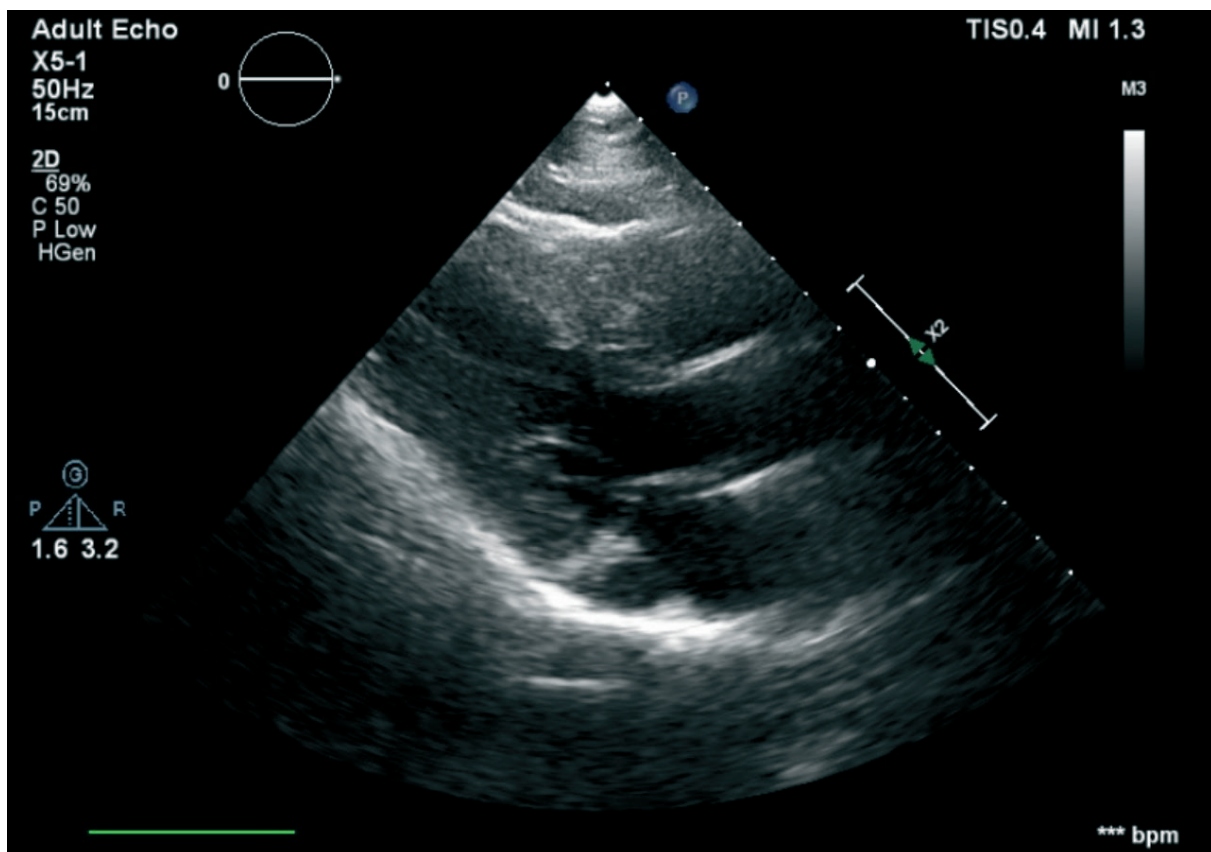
Echocardiographic image
